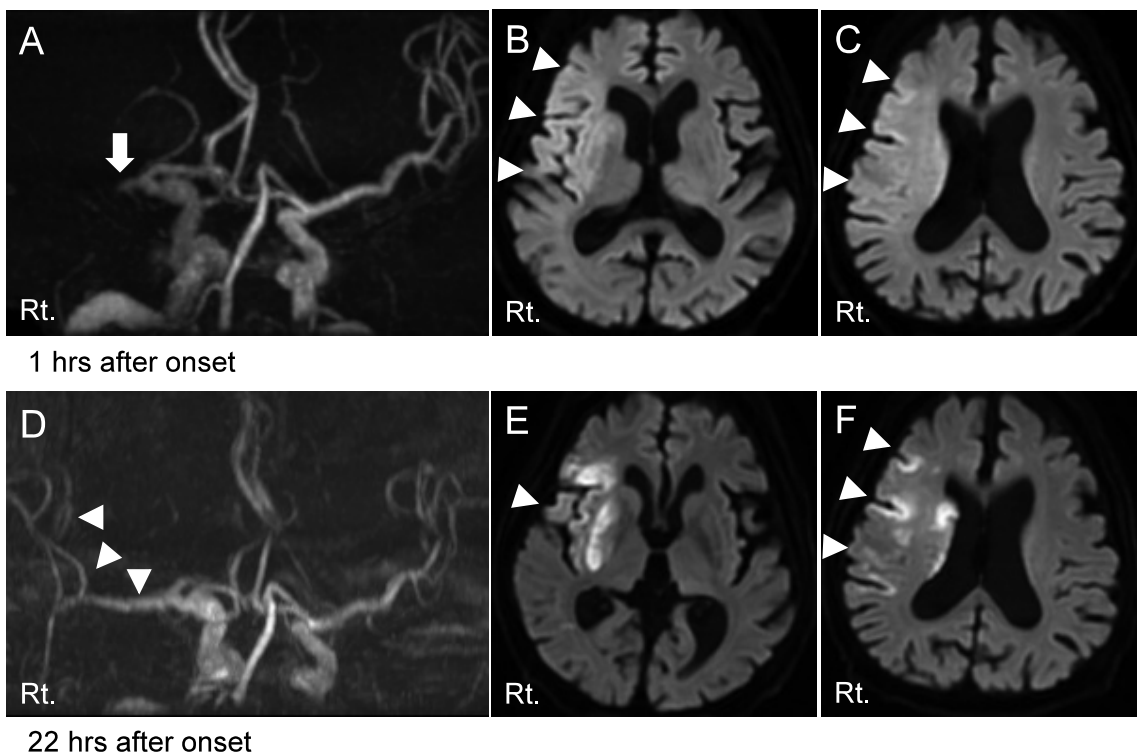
A : MRA shows occlusion of right MCA at the stem 1.0 hour after onset (arrow). B, C : DWI shows a slight hyperintensity at the right MCA territory (arrow head). D : MRA shows recanalization of right MCA at the stem 22 hours after onset (arrow head). E, F : DWI shows a bright hyperintensity at the cortex and basal ganglia of right MCA territory with recanalization of MCA (arrow head). MRA, magnetic resonance angiography ; MCA, middle cerebral artery ; DWI, diffusion-weighted imaging.
